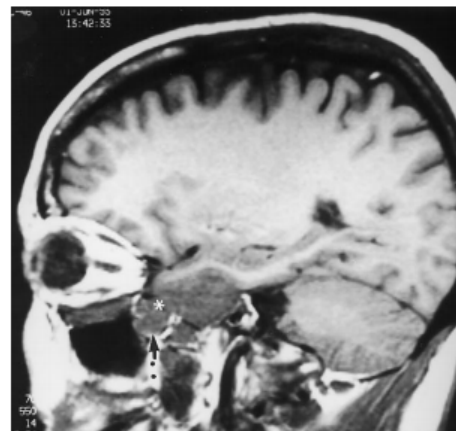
MRI sagittal T1W image showing neoplastic infiltration into the pterygopalatine fossa.
